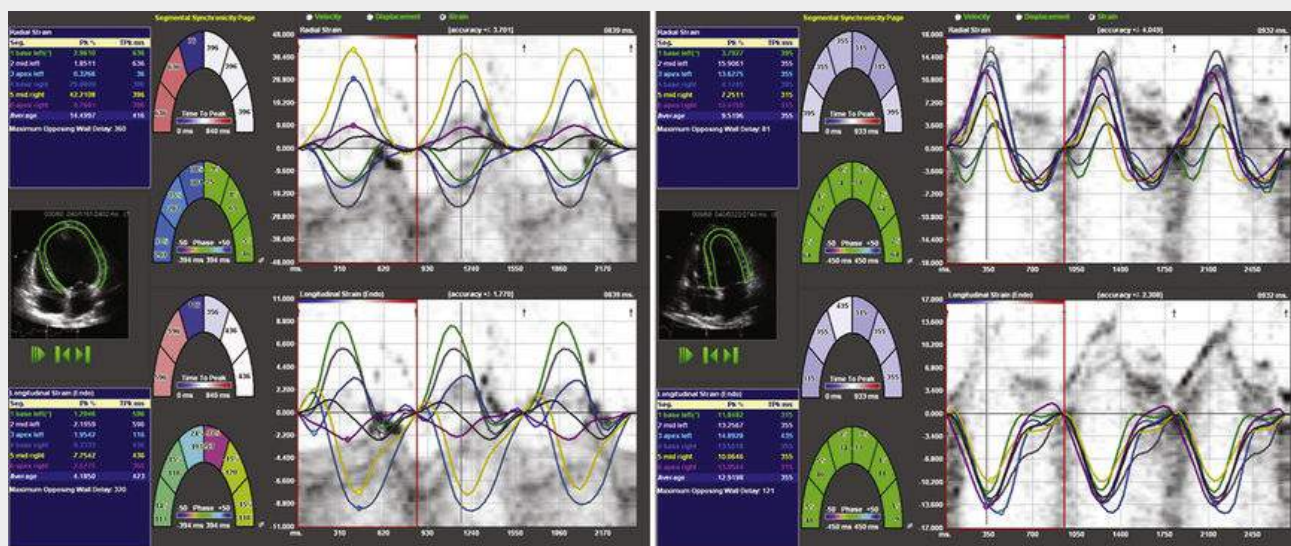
Dyssynchrony versus synchrony, as assessed by myocardial strain before and after CRT. Average radial and longitudinal strain is calculated from six different regions in the ventricle on apical four-chamber views. The waveforms depicted demonstrate both timing and magnitude of peak strain in these regions. Left panel shows a patient with cardiomyopathy before therapy with a cardiac resynchronization device. Right panel shows same patient after 12 months of CRT with dramatic improvement in ventricular synchrony.
